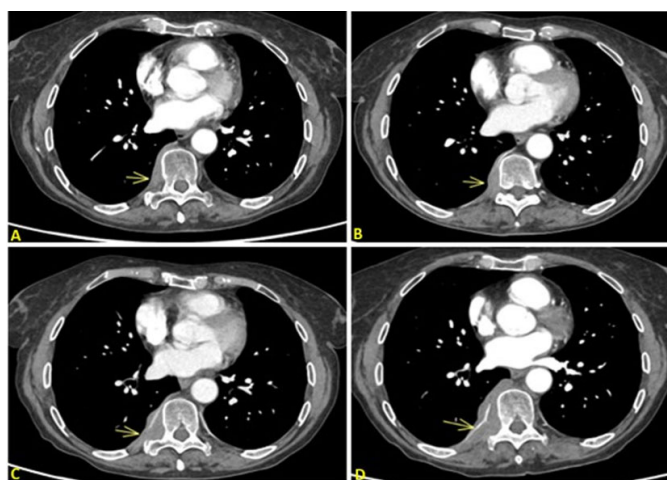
Biopsy confirmed indolent relapsed follicular lymphoma with CT features of progressive enlargement of right thoracic paravertebral soft tissue from January 2024 (A), April 2024 (B), October 2024 (C), and April 2025 (D). This was a separate entity unrelated to the esophageal malignancy.
